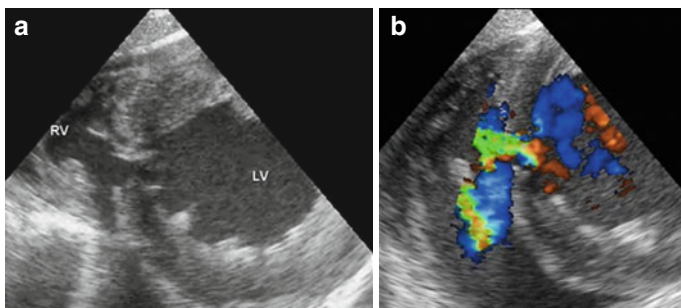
TOE view of a moderate mid-muscular VSD with 2D imaging (a) and colour flow Doppler (b). Note that the TOE view gives a less ‘surgical orientation’ of the defect and requires more spatial awareness from the operators compared with the epicardial scan. *RV* right ventricle, *LV* left ventricle
